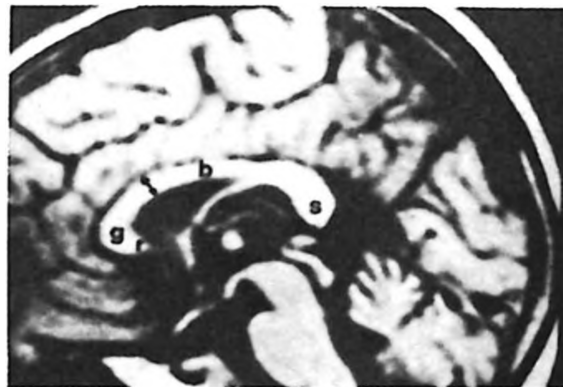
Measurement of the thickness of genu at the anteroposterior length of the CC. T1-weighted sagittal image shows normal appearance of CC. r: rostrum, g: genu, b: body, s: splenium.
